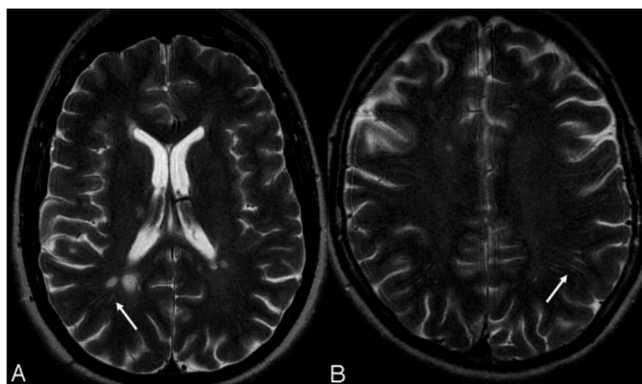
(A) On a T2-weighted image (TR/ TE, 7900/119) of a 51-year-old patient with relapsing-remitting MS (RRMS), the prominent perivenular space sign (arrow) traces the central course of the veins alongside which the lesions have spread. (B) A 33-year-old patient with RRMS demonstrates the prominent perivenular spaces sign (arrow) on a T2-weighted image which appears to be unrelated to lesions. Image adapted from (Ge et al., 2005) with permission granted by Dr. Yulin Ge and the publishing journal.
